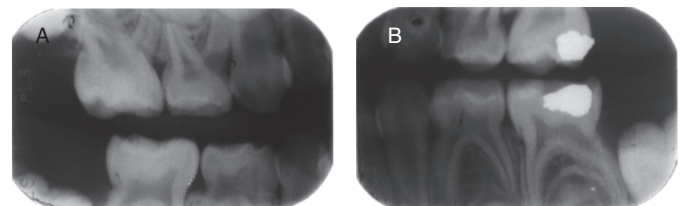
Pre-op right and left bitewing radiographs
